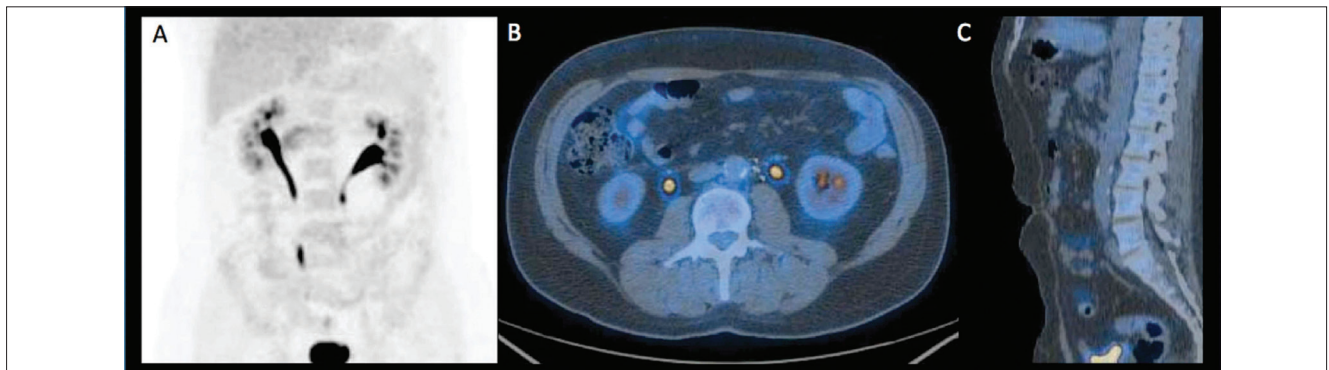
(A) MIP, (B) transaxial and (C) sagittal ¹⁸F-FDG-PET/CT fused image performed after 6 months from the beginning of therapy with prednisone and methotrexate which didn't show ¹⁸F-FDG uptake.
